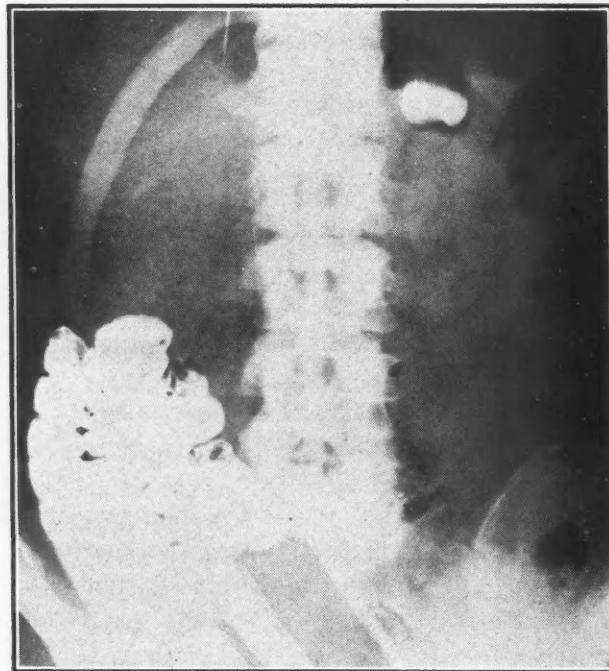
Roentgenological examination performed six hours after the ingestion of barium shows the gastric diverticulum partially filled with barium. Mucosal folds are seen running vertically.
